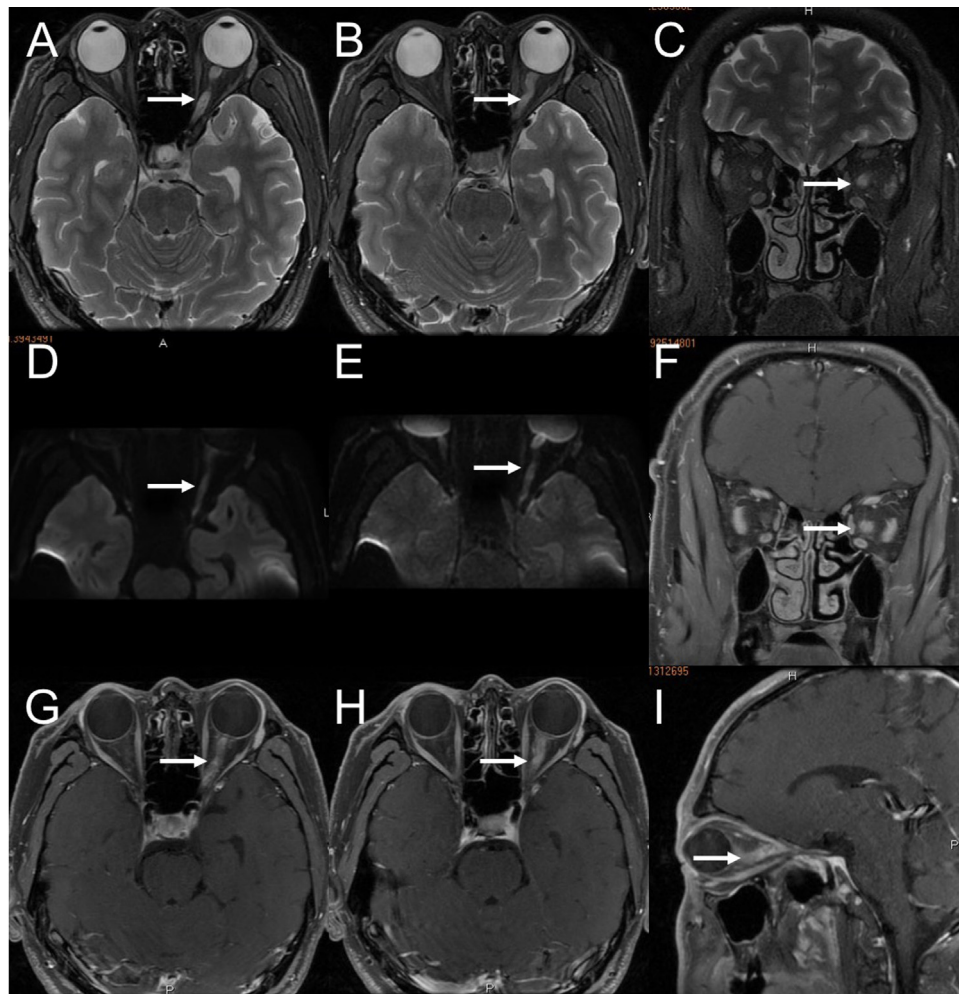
Brain MRI in Jan 2016 showing hyperintense T₂ lesions (A, B, C) and hyperintense DWI signals (D, E) in the left optic nerve with gadolinium enhancement on a T₁ sequence (F, G, H, I).
